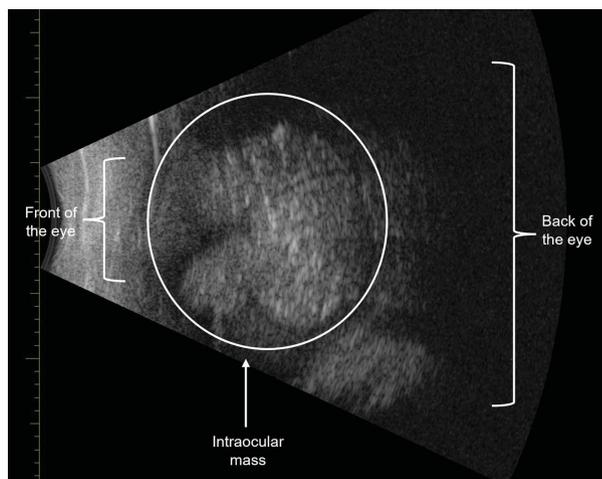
B-scan ultrasonography of the right eye demonstrates an intraocular mass with calcifications occupying more than 50% of the globe. The intraocular mass is circled with the front of the eye to the left of the figure and the back of the eye to the right.
